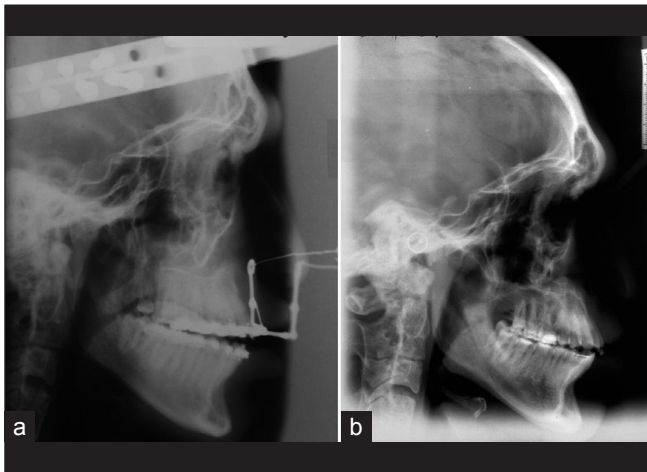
Lateral cephalometric radiograph during the distraction (a) and postoperatively (b) showing marked advancement of the maxilla
